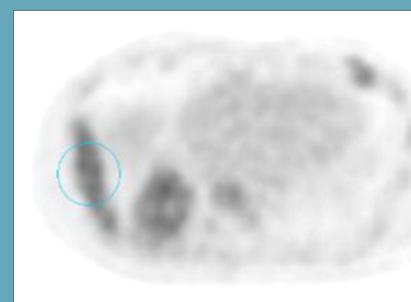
Follow up PETCT at 3 months post treatment. Max SUV 2.4.
